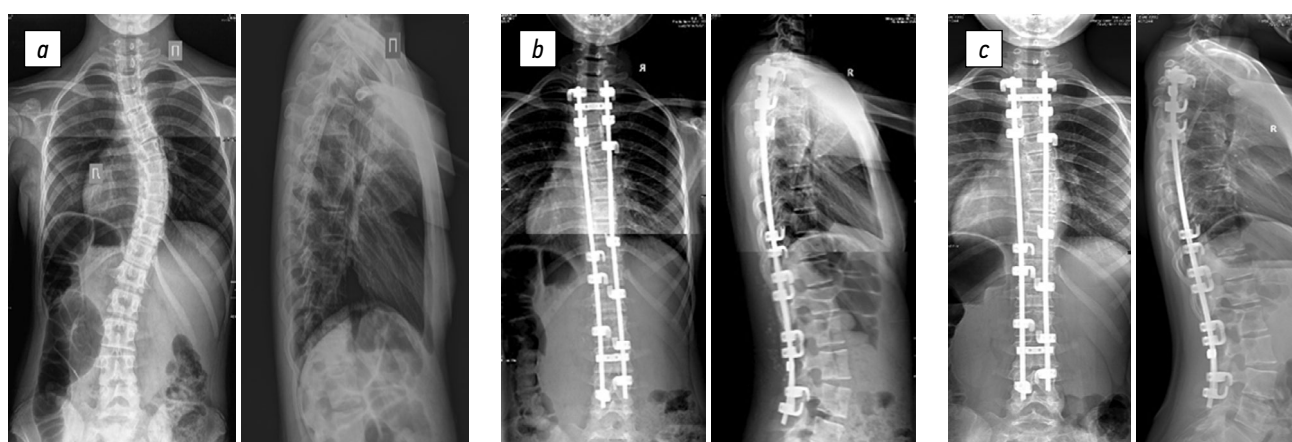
Radiographs of a 10-year-old female patient in two views: *a* — preoperative image of degree IV scoliotic deformity (50° according to Cobb) with equivalent right-sided thoracic and left-sided lumbar curves, thoracic kyphosis of 29°, and lumbar lordosis of 57°; *b* — surgical correction of scoliotic deformity of the spine using total transpedicular fixation without ventral intervention results in main thoracic curve of 11°, lumbar anti-curvature of 8°, thoracic kyphosis of 19°, and lumbar lordosis of 45°; *c* — X-ray control 6 years after the surgery revealed the main thoracic curve of 11°, lumbar anti-curvature of 8°, thoracic kyphosis of 19°, and lumbar lordosis of 57°
